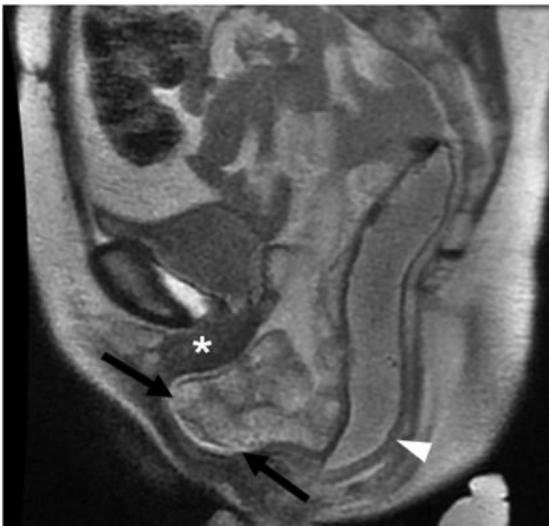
Cul-de-sac hernia. Sagittal MRI T2WI shows elevator hiatus enlargement, vaginal vault prolapse (white asterisk), rectocele (white arrow head) and peritoneocele (black arrows).
